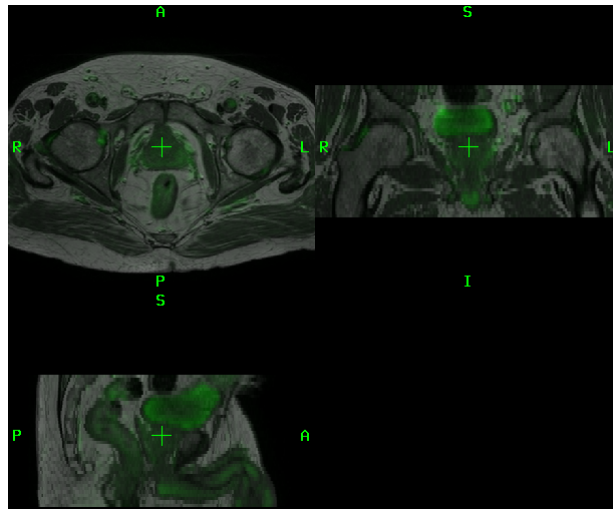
DWI registration.
